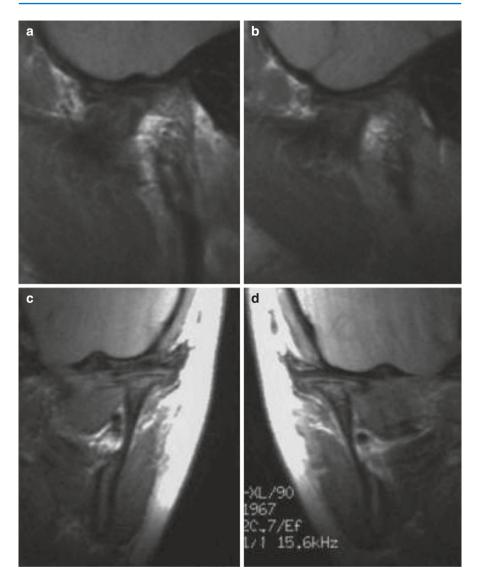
Case 2: MRI scans of the TMJs. (a) Left TMJ sagittal view. (b) Right TMJ sagittal view showing the destruction of the condyle and articular eminence, common in JIA cases. Notice the "mushrooming" of the remainder of the condylar neck process. (c) Left TMJ coronal view. (d) Right TMJ coronal view demonstrating the severe narrowing of the condylar neck stump
